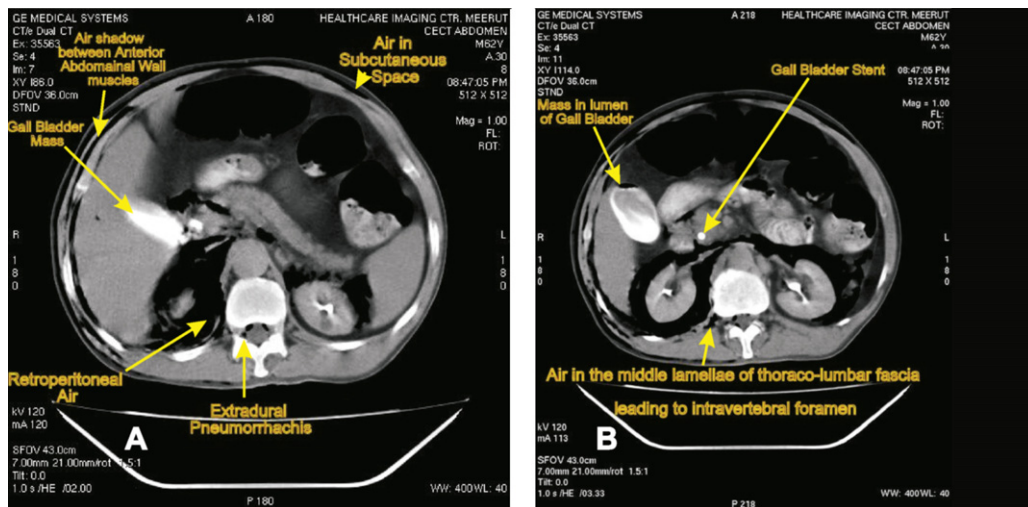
(A) Contrast enhanced CT scans show air shadow is seen in the retroperitoneal space and in the epidural space of the spinal canal. It is also seen in the subcutaneous layers of the body wall. (B) A mass is seen in the lumen of the gall bladder and the common bile duct stent is shown. Air shadow is seen in the middle lamellae of the lumbar fascia between quadratus lumborum and erector spinae muscle (C). The intervertebral disc is shown and no degenerative changes, air bubbles are visible. (D) The path of air is shown from the pararenal space, between psoas major and quadratus lumborum, intervertebral canal to the epidural space of the spinal canal. Correlate with (A).
